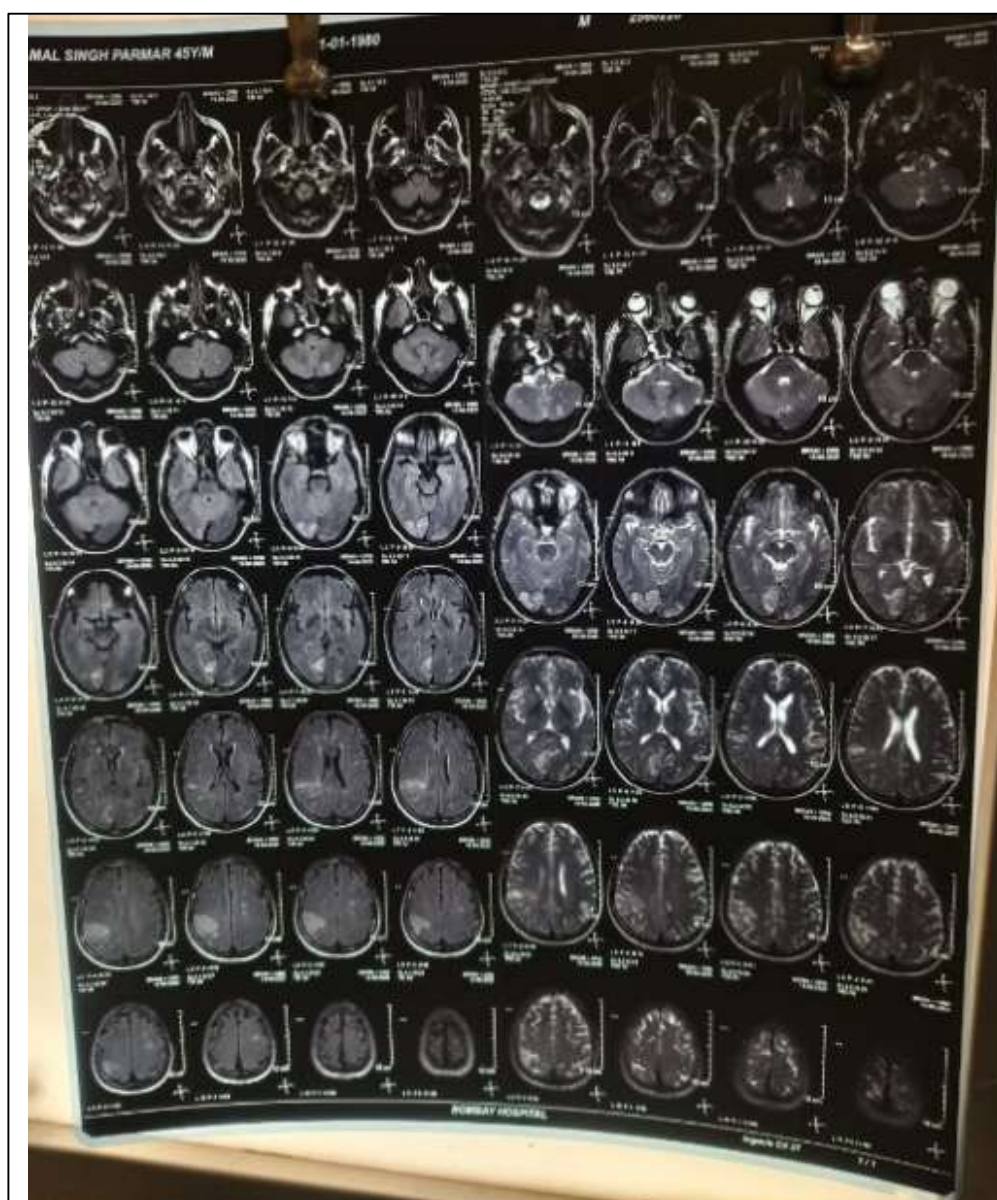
MRI brain showing multiple acute infarcts in bilateral cerebral and cerebellar hemispheres (watershed zones) with secondary hemorrhagic conversion in the right parieto-occipital region (PCA territory)
